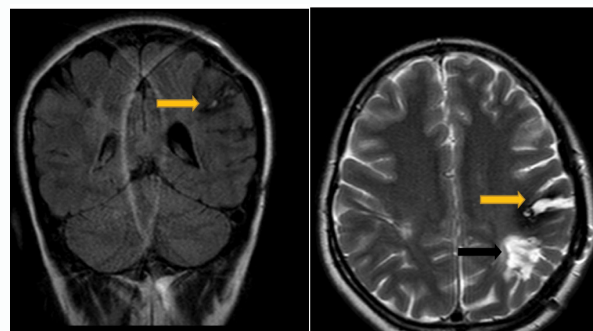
Two dimension postoperative MRI, the yellow arrows showing post-resection cavity, the black arrow showing changes on the cavernous malformation post radiosurgery.
